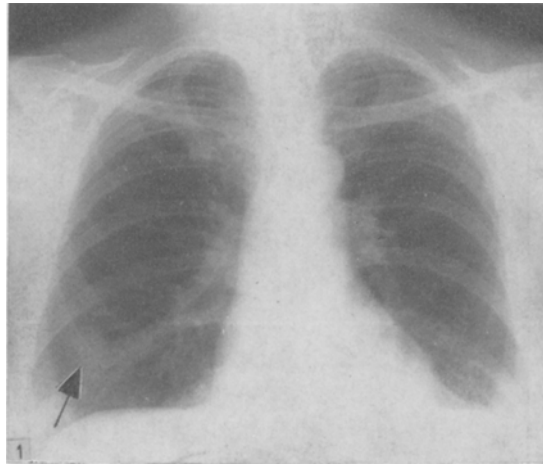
Case 3: Preoperative chest X-ray of a 58-year-old woman with a single pulmonary metastasis of the right lower lobe
